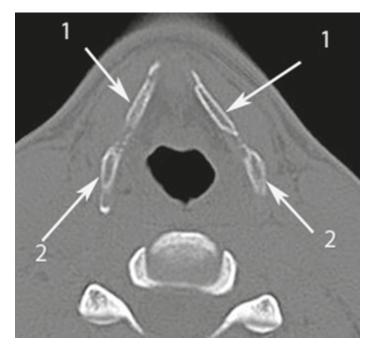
Axial CT scan at the level of hyoid bone. *Numbers* with *arrows* denote the following anatomical structures: 1 – the lateral borders of the greater horns of hyoid bone; 2 – the greater horns.
